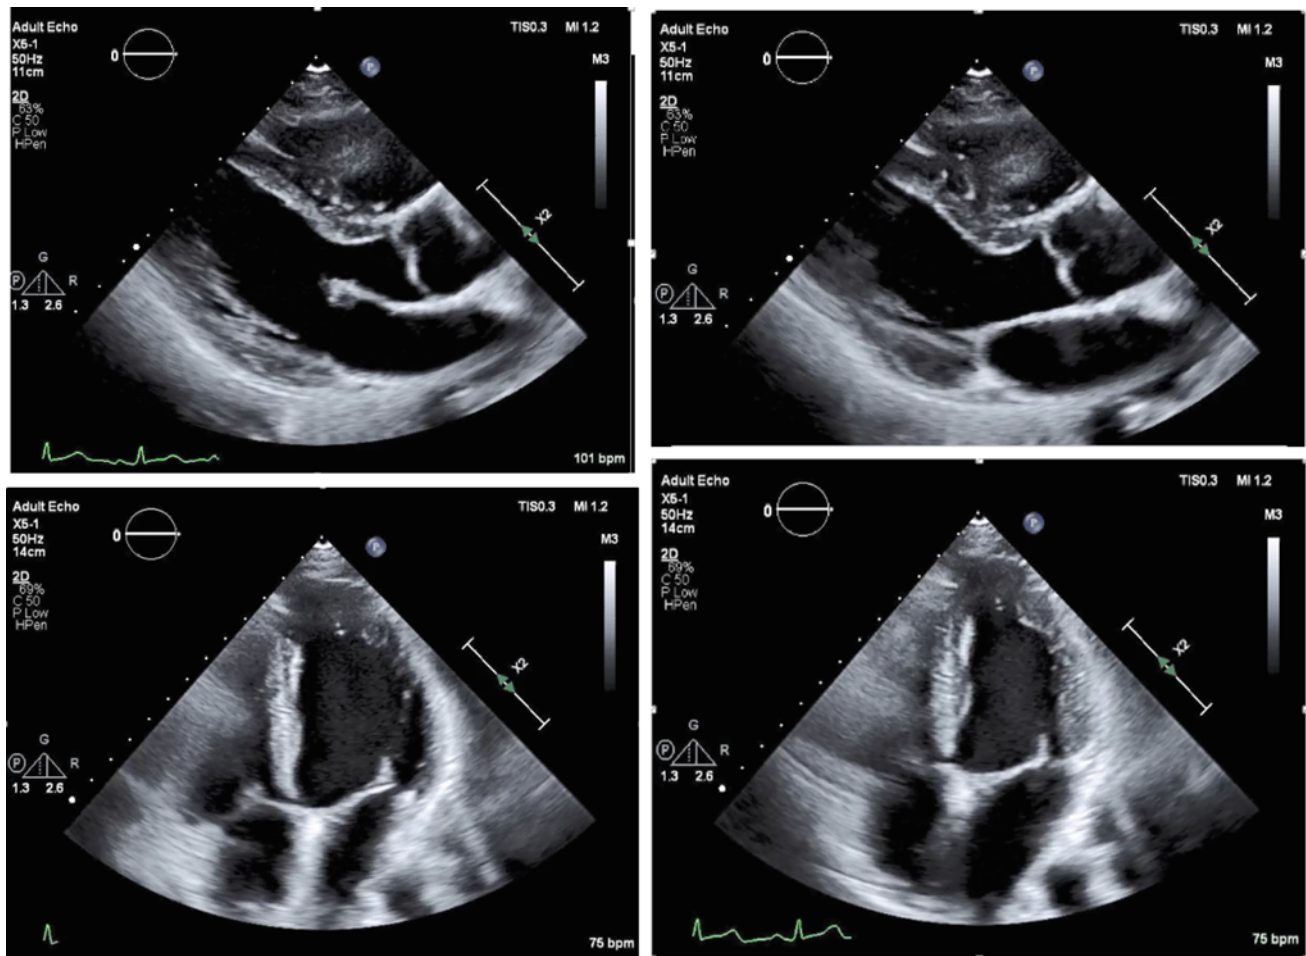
Improved LV systolic function after cardioprotective strategy with carvedilol and dexrazaxane. LVEF 57% seen in parasternal long axis views (Top left: end diastolic frame; top right:
